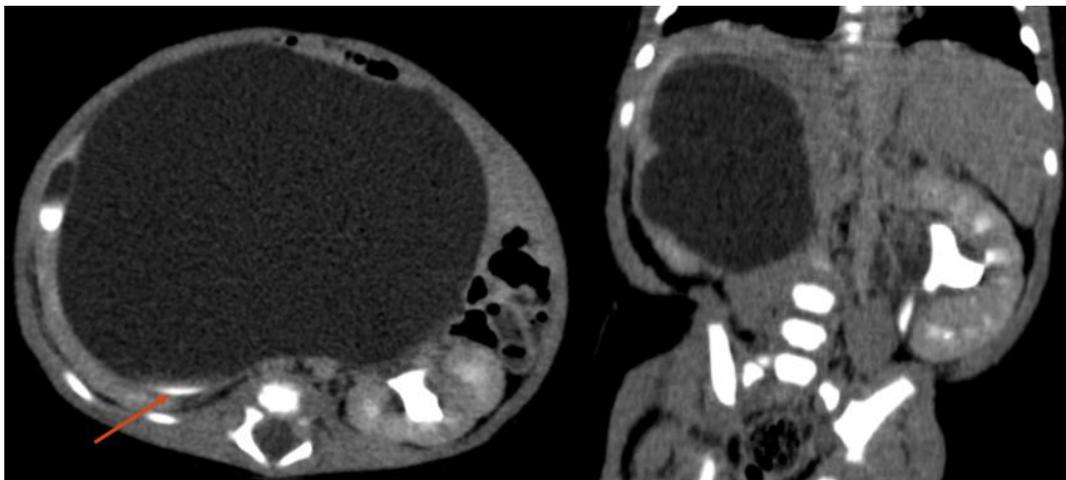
Axial (a) and coronal (b) Multiplanar CT excretory phase demonstrating a giant cystic mass occupying the right side of the abdomen and middleline and showing the contrast is excreted into the calices and into the renal collecting systems
